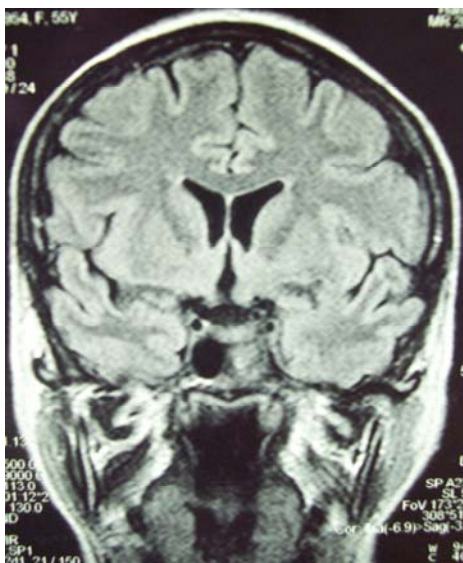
Magnetic resonance imaging (MRI) focussed on sellar and parasellar region – infiltration of the left cavernous sinus.
